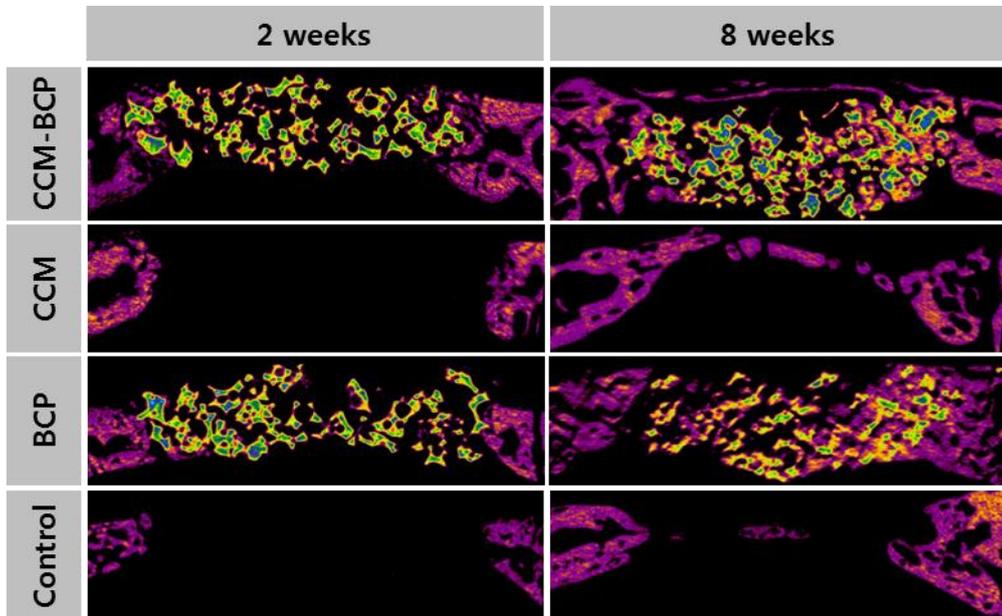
Color coded cross-sectional radiographic view of the defects at 2 and 8 weeks.
